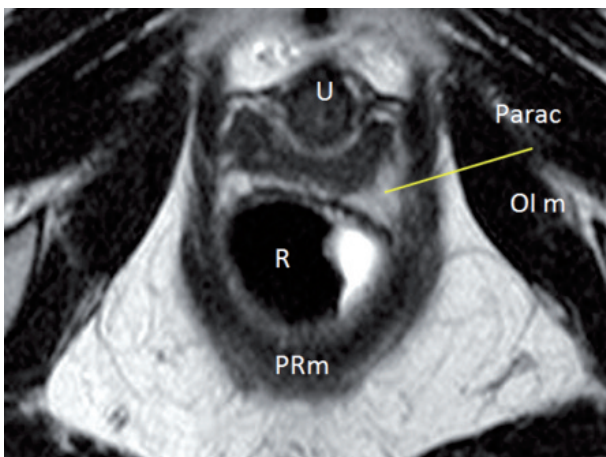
The paracolpium on axial T2-weighted TSE image is depicted as an hyperintense structure surrounding the vaginal walls (*continuous line*). Parac= paracolpium; U= urethra; OIm= obturator internus muscle; PRm= puborectalis muscle; R= rectum.
